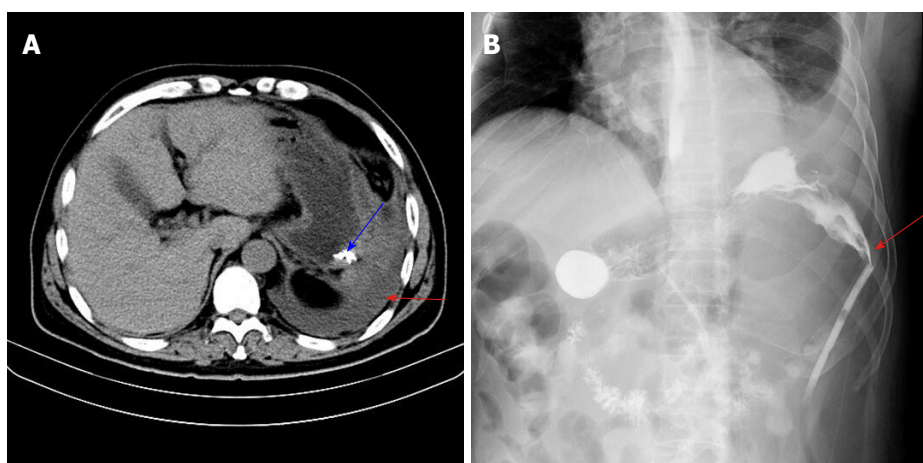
Upper abdominal computed tomography findings. A: Upper abdominal computed tomography examination indicated a large amount of effusion in the left upper abdominal cavity (red arrow), and enhanced lesions and a hematocoele in the drainage tube (blue arrow); B: Upper digestive tract ioversol angiography showed contrast agent overflow from the greater curvature of the gastric body to the abdominal drainage tube (arrow).
